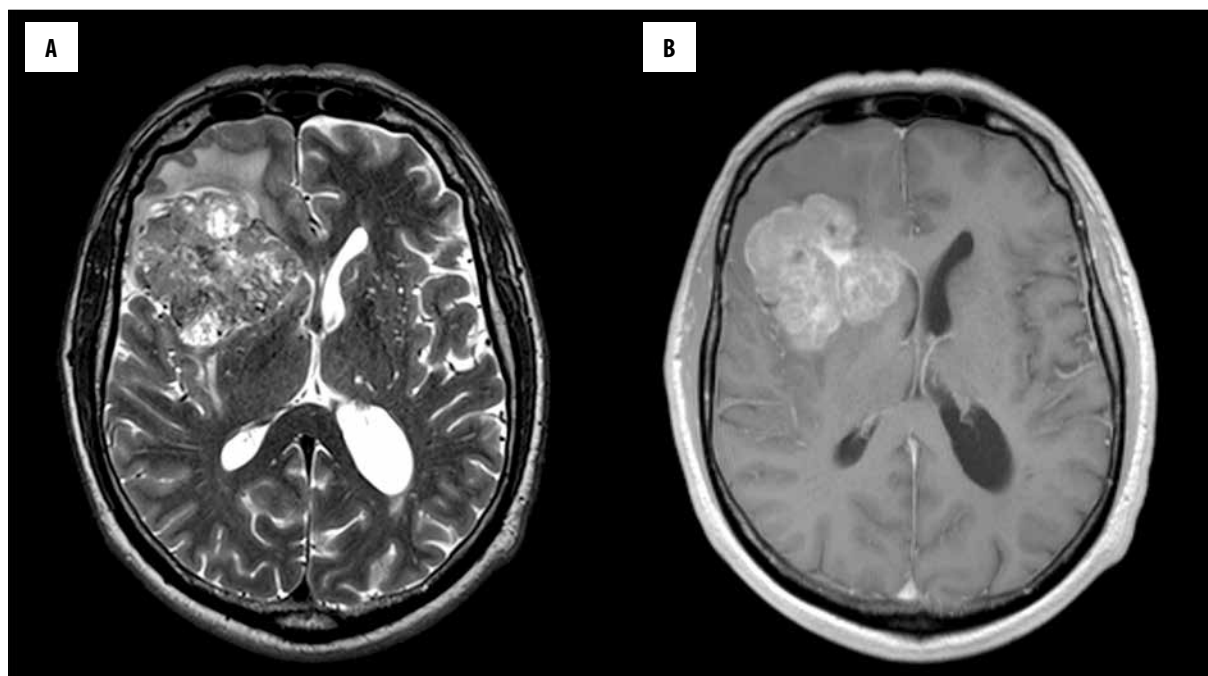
MRI brain scan showing tumour mass located in the fronto-temporal region of the brain. (A) T2-weighted image and (B) T1-weighted image after i.v. contrast enhancement
